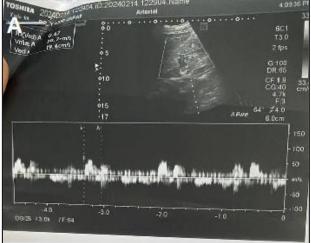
(A and B): Doppler ultrasound at presentation.
